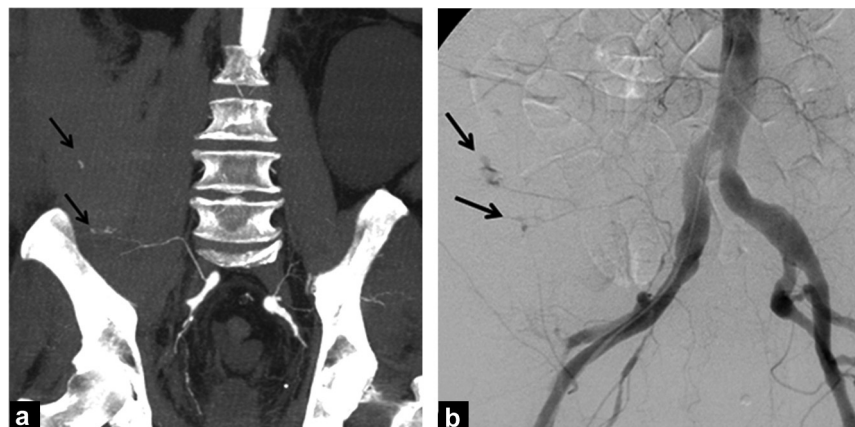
Computed tomography angiography (a) and arteriography (b) in a 78-year-old patient presenting with a hematoma of the right psoas muscle with no anticoagulant overdose (INR 2.2). (a) shows the active leak of contrast material (black arrows) and identifies the iliolumbar artery as the source of the hemorrhage. Selective arteriography of the right iliolumbar artery confirms extravasation (black arrows).
